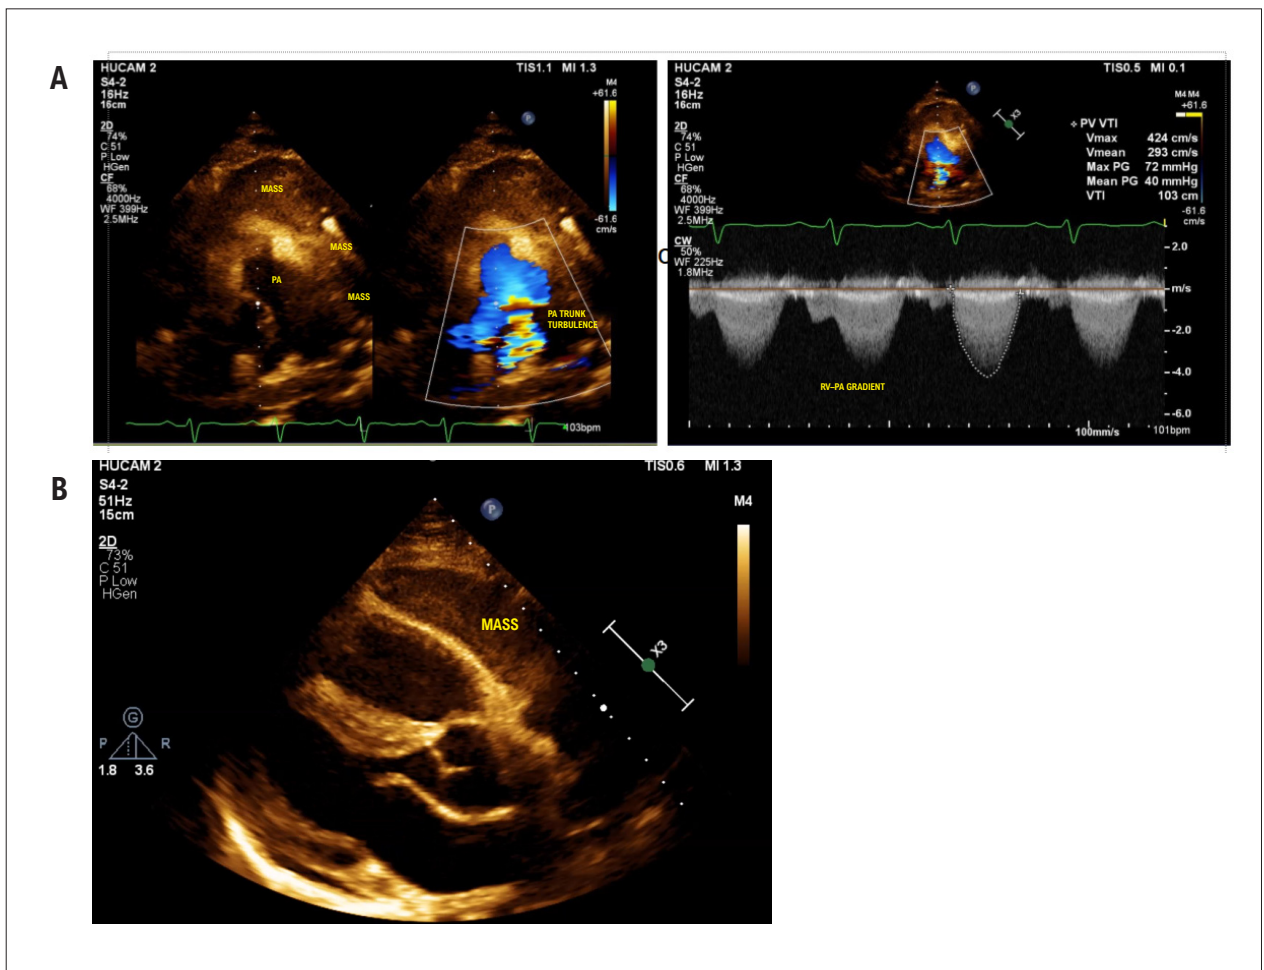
A) Parasternal short-axis view, showing the mass causing pulmonary stenosis. B) Parasternal long-axis view, showing the presence of a mass compressing the right ventricle. PA: pulmonary artery; RV: right ventricle.
